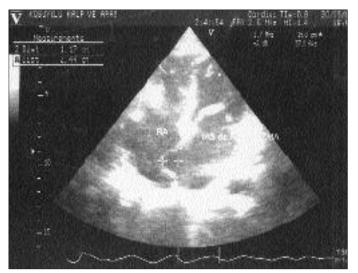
Four-chamber transthoracic echocardiographic view of atrial septal aneurysm in a patient with mitral valve stenosis
